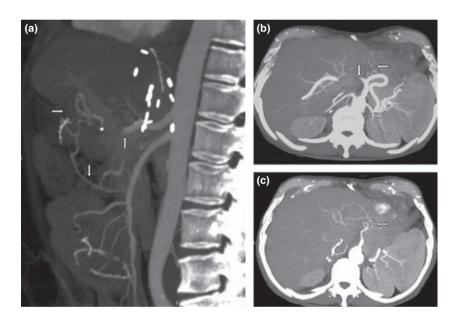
Angio CT-scan of patient 2 (lateral view). (a): arrows denote complete common hepatic artery thrombosis (↑) and liver parenchyma arterial neovascularization (⇒) from the first jejunal artery originating from the superior mesenteric artery (↓) in the case of Roux-en-Y anastomosis. (b and c): CT-scan of patient 8. Arrows indicate complete common hepatic artery occlusion (↓) and new parenchyma neovascularization (NV) originating from the left gastric artery (⇐).
